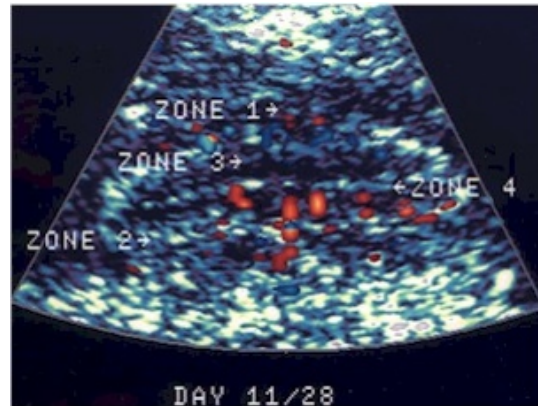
Vascular penetration on Power Doppler to Zone 4
